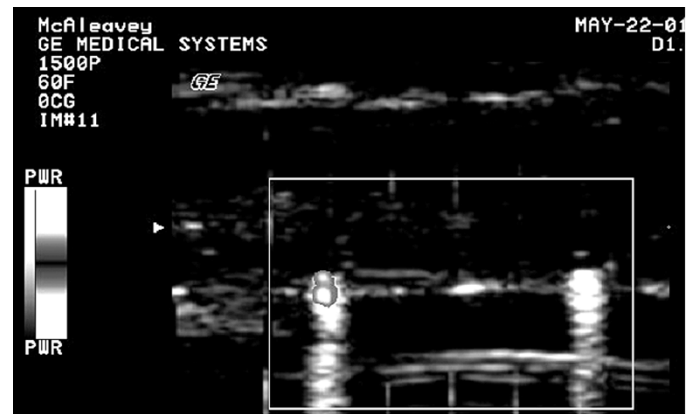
Power Doppler image of steel (left) and copper (right) seeds in agar. Note the highlighting of the steel seed by Power Doppler, and the absence of a Doppler signal about the copper seed.
